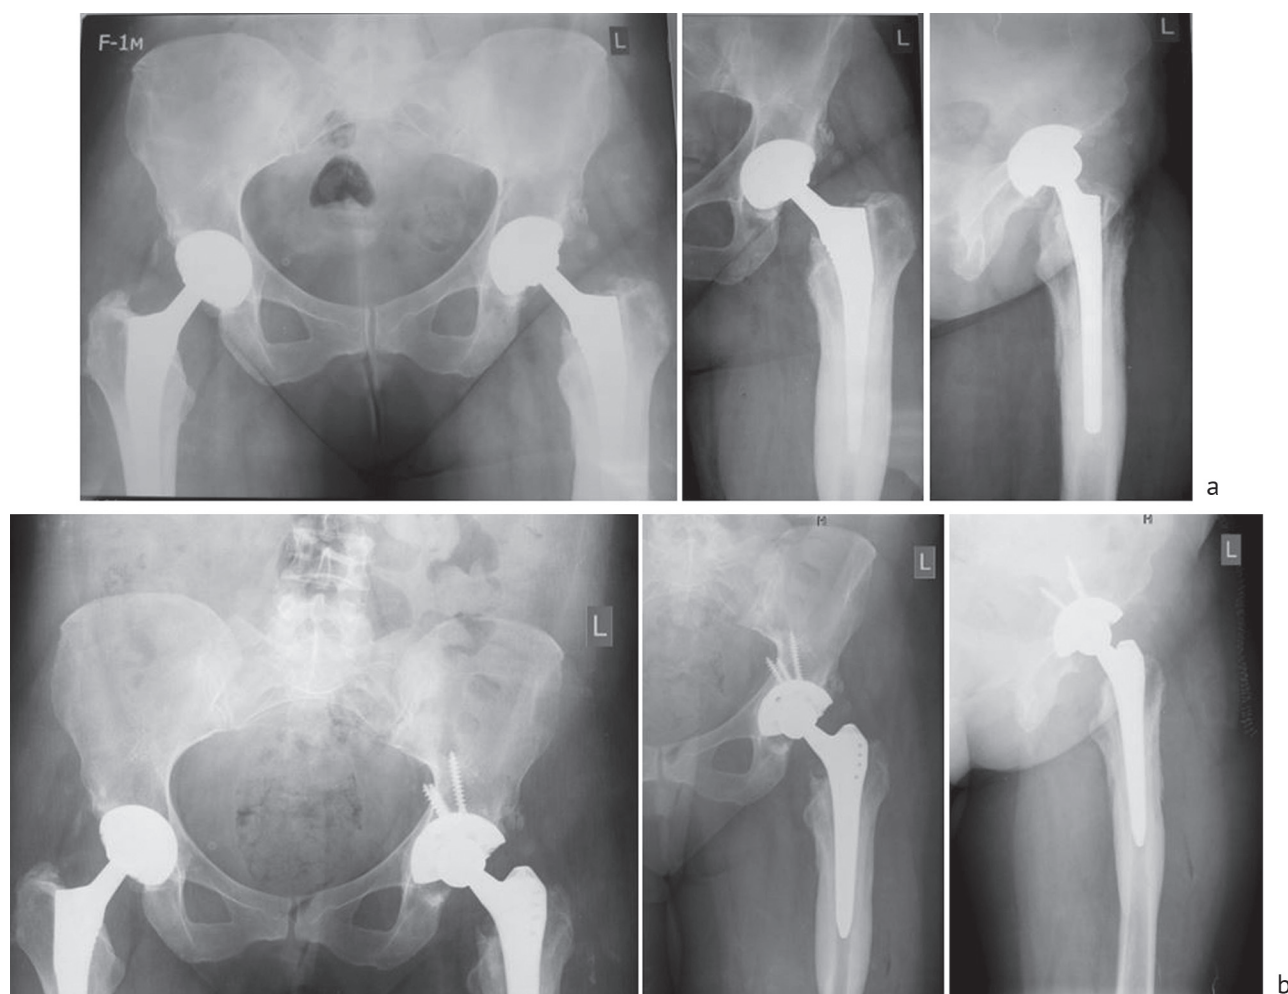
Radiographs of the pelvis and hip joint: a before treatment: b after treatment
